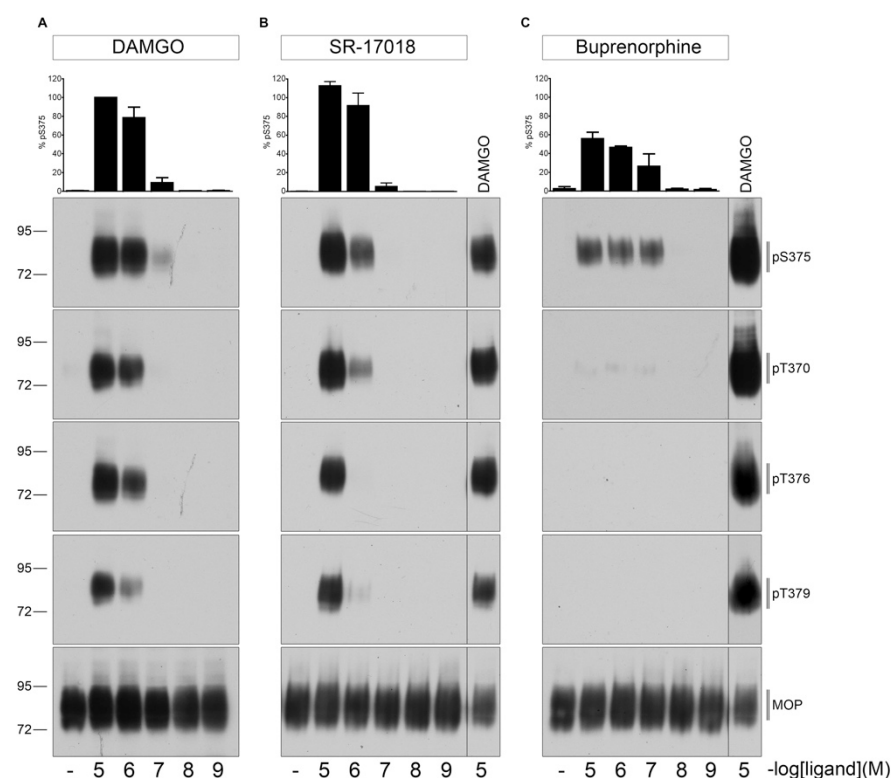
Dose-dependent multisite phosphorylation by DAMGO, SR-17018, and buprenorphine. HEK293 cells stably expressing HA-MOP were either treated with (A) DAMGO, (B) SR-17018, or (C) buprenorphine with concentrations ranging from 10 μM to 1 nM for 30 min at 37 °C. Cells were lysed and immunoblotted with the anti-pT370 (pT370), anti-pT376 (pT376), anti-pT379 (pT379), or anti-pSer375 (pS375) antibodies. Blots were stripped and reprobed with the phosphorylation-independent anti-HA-tag antibody to confirm equal loading of the gels. S375 phosphorylation was quantified (upper panel) and expressed as percentage of maximal phosphorylation in control cells, which was set at 100%. Data correspond to mean \pm SEM from three independent experiments. Positions of molecular mass markers are indicated on the left (in kDa). ((B,C) right lane) 10 μM DAMGO samples were used as a control to visualize different development times on X-ray films. Blots are representative of three independent experiments.
